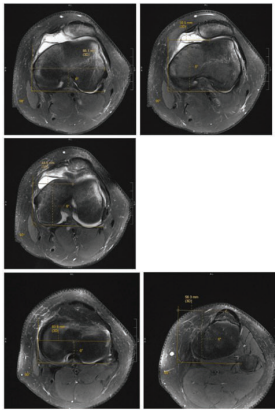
Determination of the position of the trochlear groove and tibial tubercle. A) The distance between the epicondyles is determined on an axial MRI image. B) Determination of the %pTGL, keeping track of the most medial aspect of the medial epicondyle, the most proximal axial image showing fully formed medial and lateral facets with a discernible trochlear groove is identified. The distance from the most medial aspect of the medial epicondyle to the apex of the trochlear groove is determined. The % lateralization of the groove is determined by dividing this distance by the inter-epicondylar distance and multiplying by 100. C) This process is repeated for the %dTGL. D) The axial MRI image that shows the widest portion of the proximal tibia is identified and it is measured relative to a line parallel to the posterior tibial condyles. E) Keeping track of the location of the medial aspect of the tibia, a more distal MRI image showing the most distal aspect of the tibial tubercle in which the patellar tendon is in full contact is identified. The distance between the most anterior aspect of the tibial tubercle and the medial aspect of the tibia is measured. This distance is divided by the width of the proximal tibia and divided by 100.
